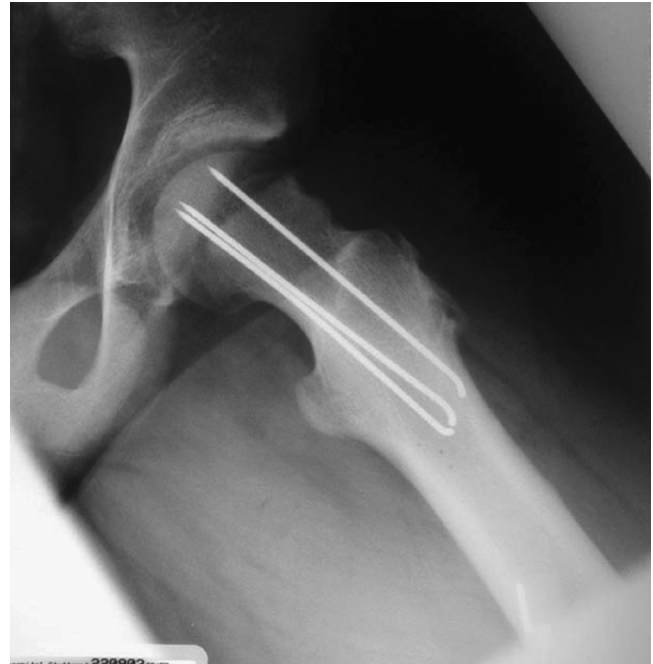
Frog lateral radiograph of left hip of patient in Figure 6 at follow-up at age 16 years 5 months.
